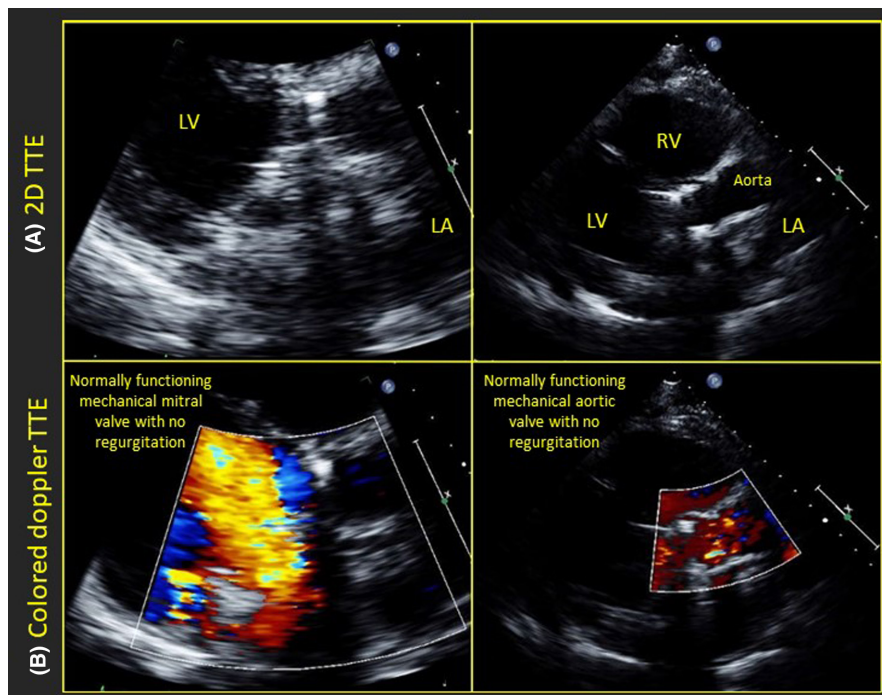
Parasternal long axis transthoracic echocardiography (TTE) view of the mitral valve (left) and aortic valve (right). (A) Is a 2D view with a normally calculated ejection fraction. (B) Is a colored Doppler view showing normally functioning mechanical mitral (left) and aortic (right) valves with no regurgitation (of note, views were limited). LA, left atrium; LV, left ventricle; RA, right atrium; RV, right ventricle.
